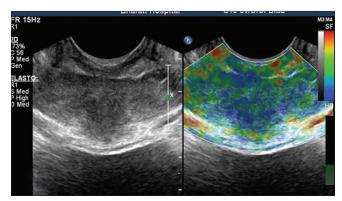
Transverse B-mode and elastography images in a 29-year-old control male with normal serum prostate-specific antigen level. B-mode ultrasound (right) shows normal prostate gland. Corresponding elastogram (left) shows no focal hardening of the peripheral zones of the prostate. Transrectal real-time strain elastography score 1 - there was no blue area or star-like blue in outer glands
